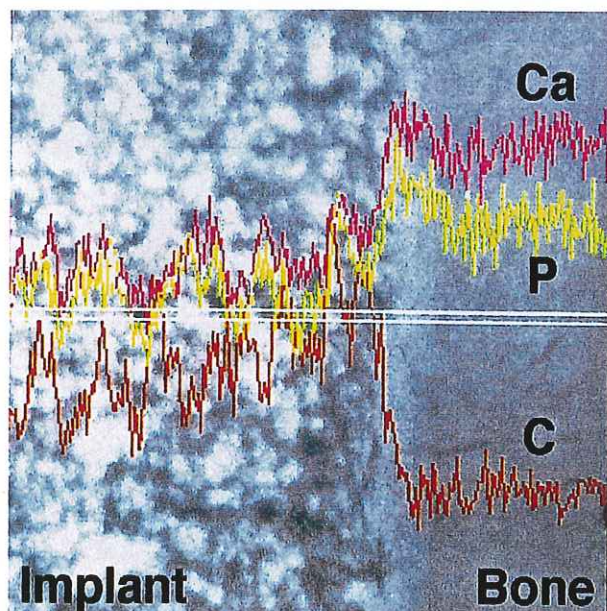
SEM-EPMA study of the interface between the u-HA50 implant and the bone at 25 weeks. (a) SEM photograph showing bone directly bonded to the implant. B, bone; I, implant. Original magnification $\times 2000$; scale bar = 10 μm . (b) SEM-EPMA photograph showing the X-ray intensities of calcium (Ca), phosphorus (P), and carbon (C) across the bone-implant interface. The amounts of Ca, P, and C changed at the bone-implant interface.
